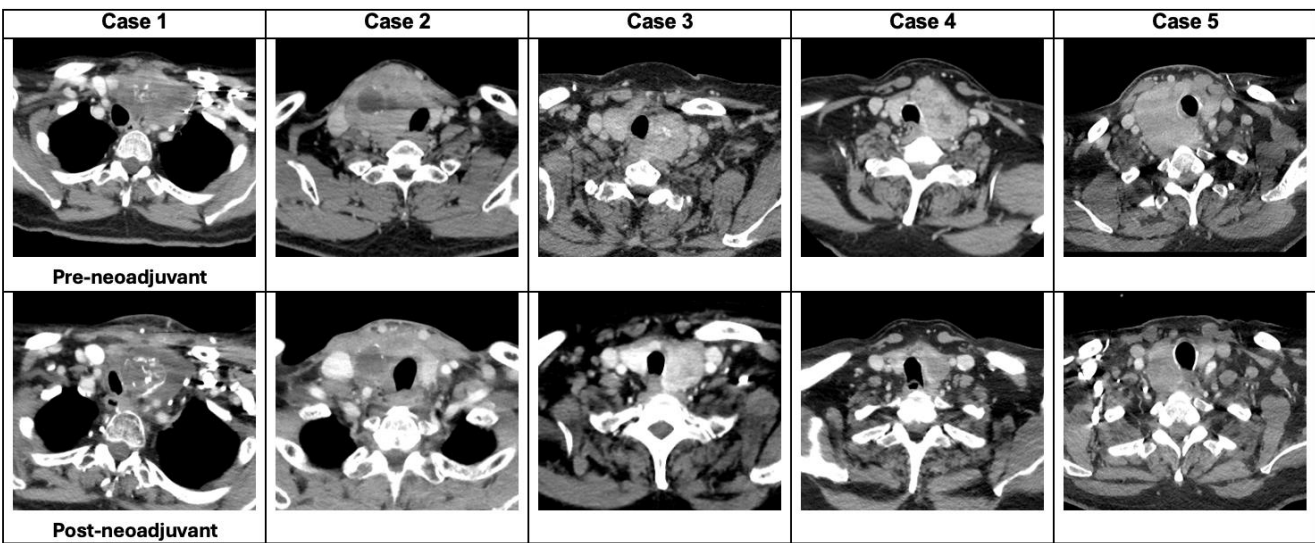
Neck CT before and after neoadjuvant therapy with lenvatinib
